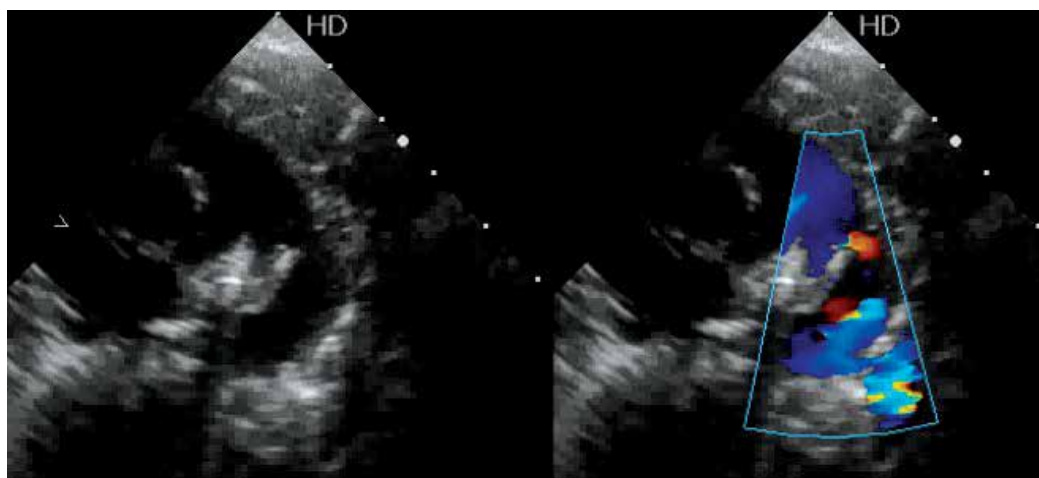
Echocardiographic parasternal short-axis image demonstrating a patent ductus arteriosus (red flow at the ductus arteriosus and blue flow at both pulmonary arteries).
